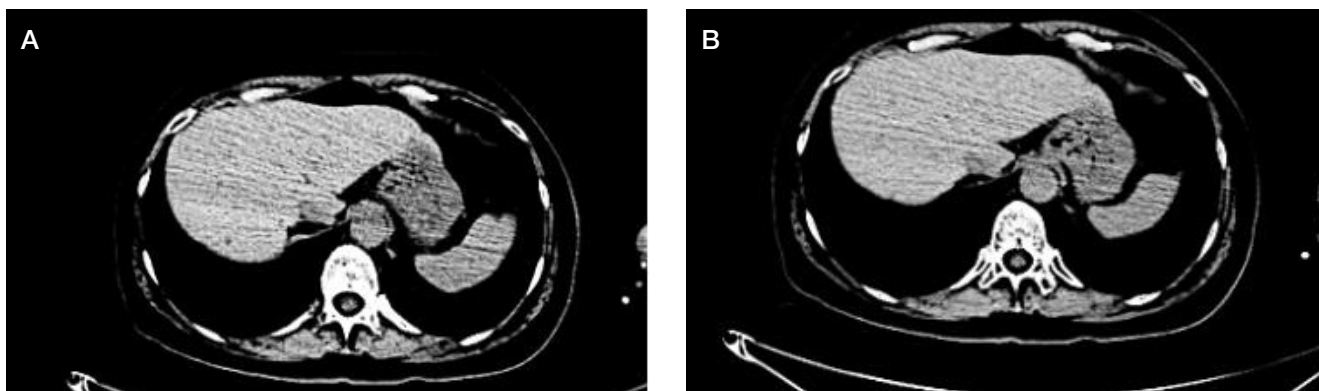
A, B. Abdominal CT, 30.11.2022. Metastatic foci (size up to 1.5 cm) in both lobes of the liver; positive dynamics compared to 26.09.2022
